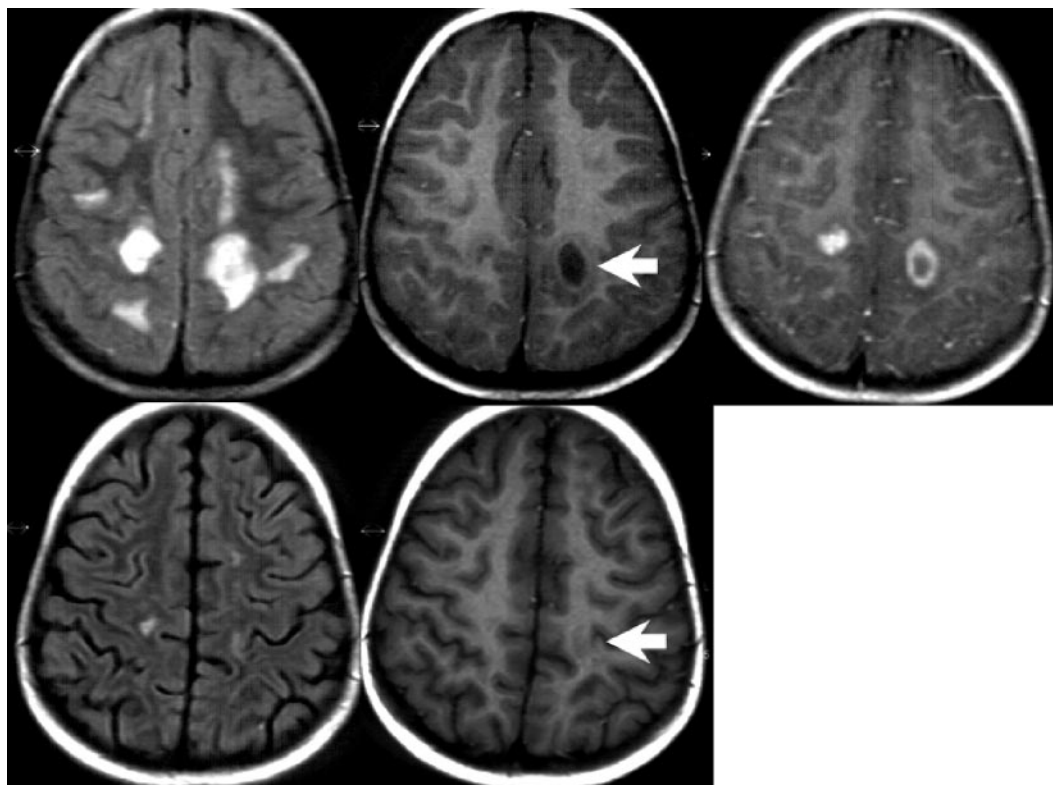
MRI findings in 1 case demonstrating typical asymmetric supratentorial lesions (top row, initial study; bottom row, 8 weeks later). Lesions are bilateral cortical and subcortical, hyperintense on FLAIR (left) and mildly hypointense on noncontrast T1 (middle, arrow) with no mass effect. Postcontrast imaging (right) shows a variable enhancement pattern including homogeneous enhancement of 1 lesion and ring enhancement of another. Eight weeks later, the lesions are nearly resolved on noncontrast studies (bottom row); enhancement was no longer seen (not shown).
